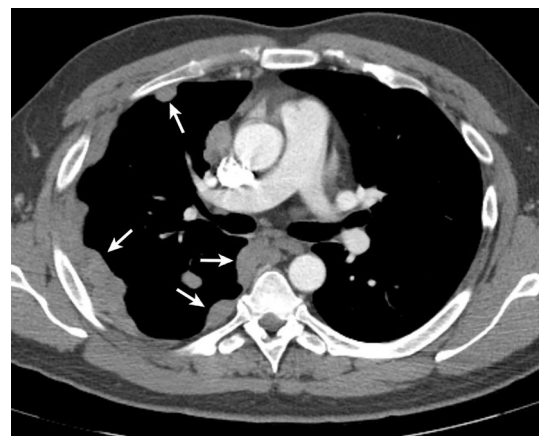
M1a disease. Contrast-enhanced axial CT of the chest shows multiple right pleural metastases (arrows) from a thymoma (not shown).
